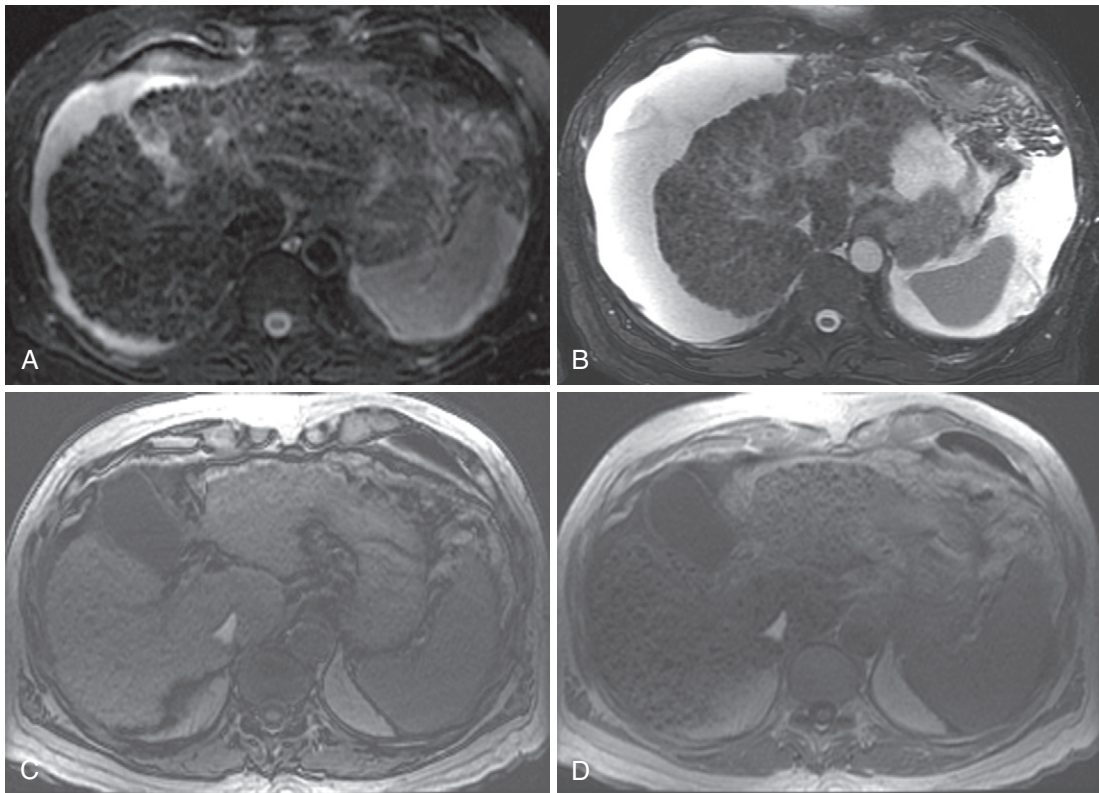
Parenchymal nodularity with bridging bands of fibrosis. The axial moderately T2-weighted fat-suppressed images at baseline (A) and follow-up (B) portray advanced cirrhosis reflected by diffuse nodularity with intervening reticular hyperintensity corresponding to fibrosis with worsening ascites. Comparing the out-of-phase (C) with the in-phase (D) images reveals susceptibility artifact arising from the parenchymal (siderotic) nodules due to their iron content.
